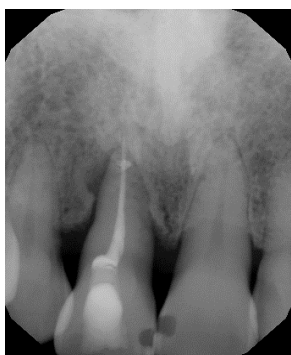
Periapical radiograph, 2 weeks post-operative.
